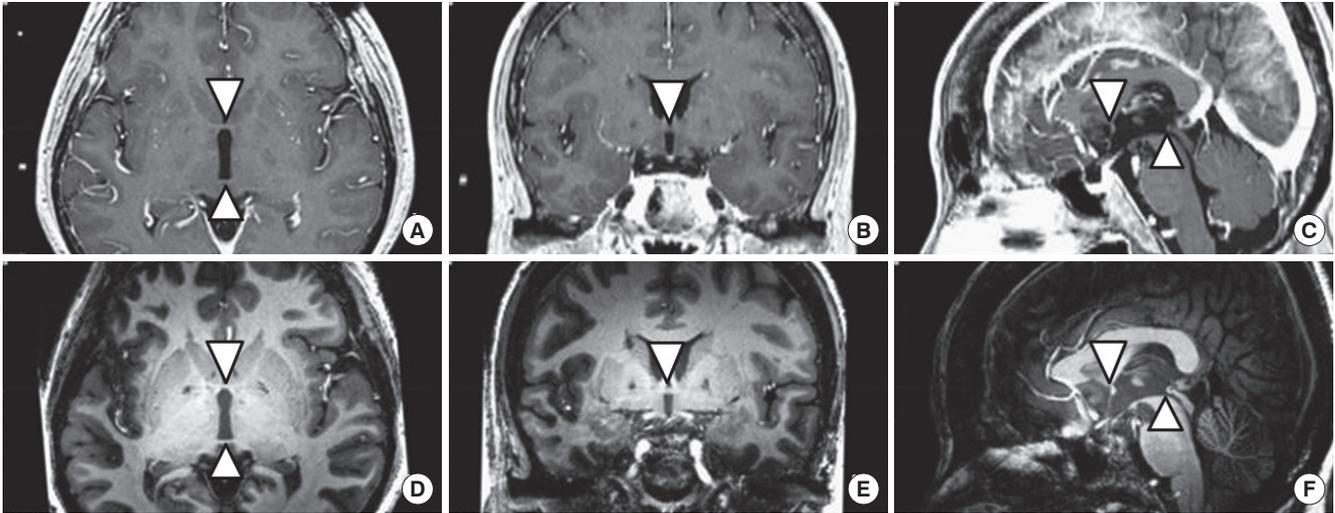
Axial, coronal, and sagittal images of the anterior commissure (∇) and the posterior commissure (Δ) in 1.5T and 7.0 T magnetic resonance images (MRI). In the co-registered images of the 7.0T MRI and 1.5T MRI, there is no significant difference in the location of the AC and PC between 1.5T (A-C) and 7.0T MRI (D-F) whereas enhanced anatomical details of the metastatic brain tumors are provided by 7.0T MRI.
